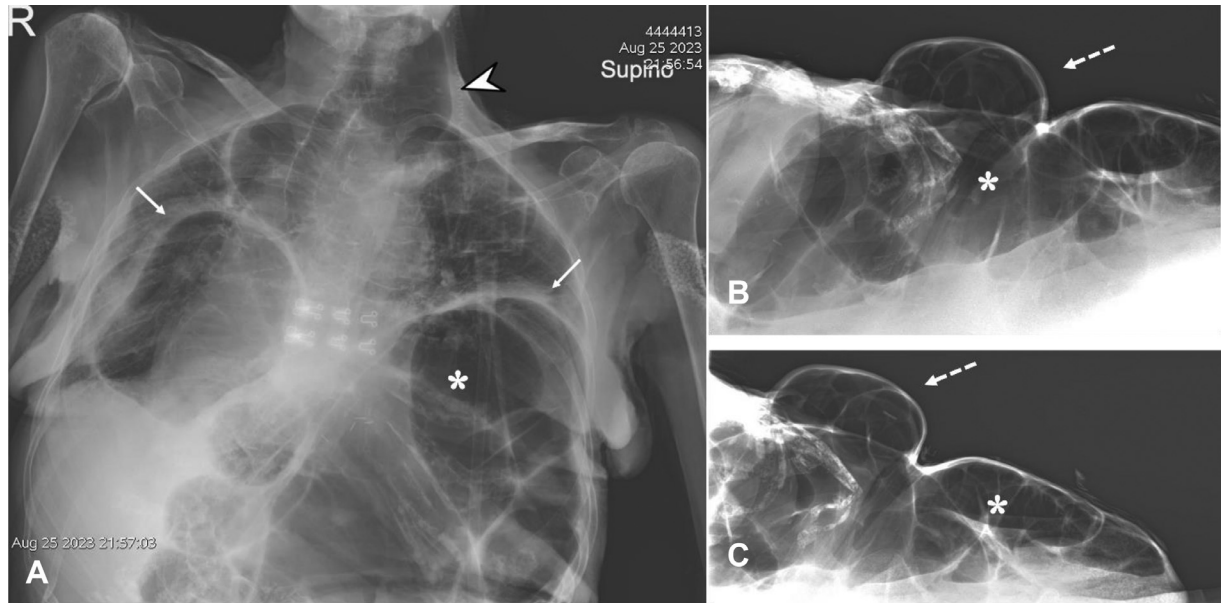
(A-C) Radiographs. Supine anteroposterior chest view (A) showing significant rise of both hemidiaphragms (arrows in A) and massive esophageal dilatation (arrowhead in A) was followed by 2 abdominal radiography in dorsal decubitus view (B, more cranial and C, more caudal) that revealed marked distension of the entire bowel (asterisks in A-C) and median laparocele (dotted arrows in B, C), without signs of pneumoperitoneum (no evidence of free air).
